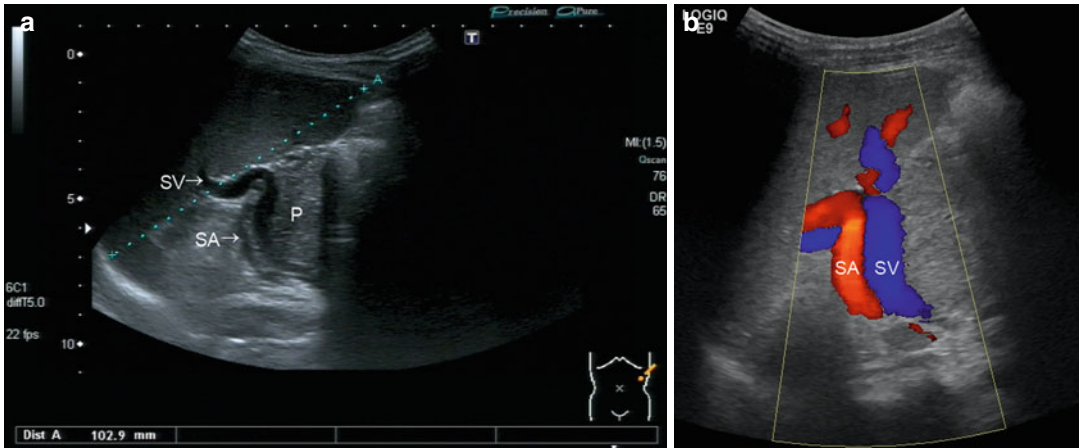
(a) B-mode section through the splenic hilus. The length of the spleen is measured. The tail of the pancreas can be visualised caudally to the splenic vein (P). The splenic artery (SA) is smaller in size and located more cranially than the splenic vein (SV). Left lateral intercostal approach. (b) Colour Doppler of the flow in the splenic
